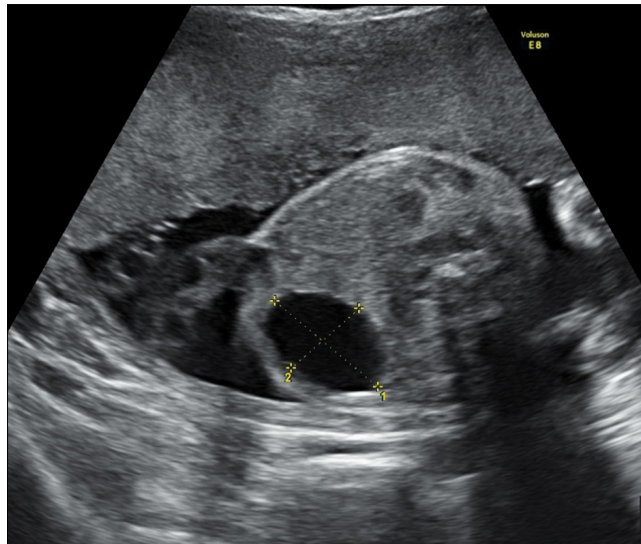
Prenatal ultrasonographic scan of the fetus documenting the increase in size to 37x24 mm at 30+6 weeks of gestation
